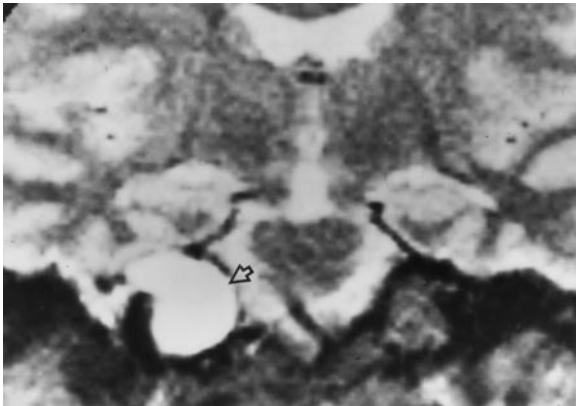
Coronal CT scan of a primary epidermoid in the petrous apex (*arrow*)
